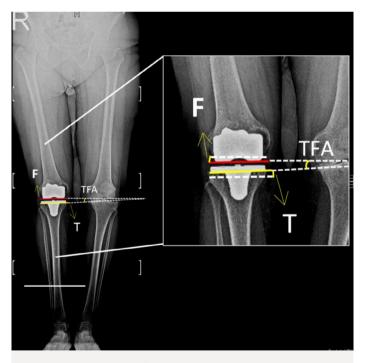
Evaluation of component orientation, including the inclination angles of the femoral and tibial components relative to the floor and the tibiofemoral angle (TFA), measured on postoperative standing long-leg anteroposterior radiographs.
